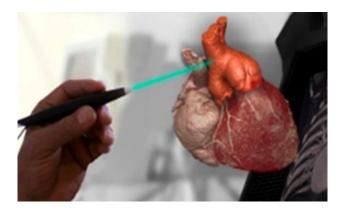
3D renders from CT images [10].
